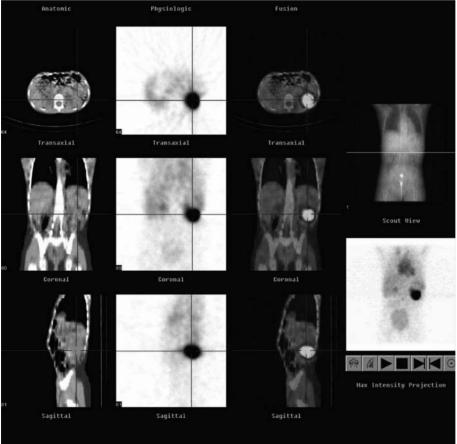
Localized pseudotumoral pattern of glomerular hyperfiltration in a case of reflux nephropathy. a US: transverse scan of the left kidney; hyperechoic ill-defined area in the external part of the kidney (marked by *arrows*). b MR imaging; T2 weighted sequence displays bilateral small irregular kidneys with distorted pelvi-calyceal systems and a "tumoral" appearance of the left kidney. c Tc 99 DMSA-SPECT-CT: the outer part of the left kidney highlights suggesting hyperfunction
